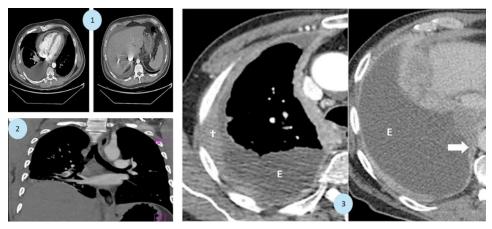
CT Imaging in Pleural Effusion and PE: Axial and coronal CT scans revealing right pleural effusion, atelectasis, and a thrombus in the pulmonary artery, alongside findings suggestive of malignancy, in the context of assessing PE presence in pleural disease (2023).
